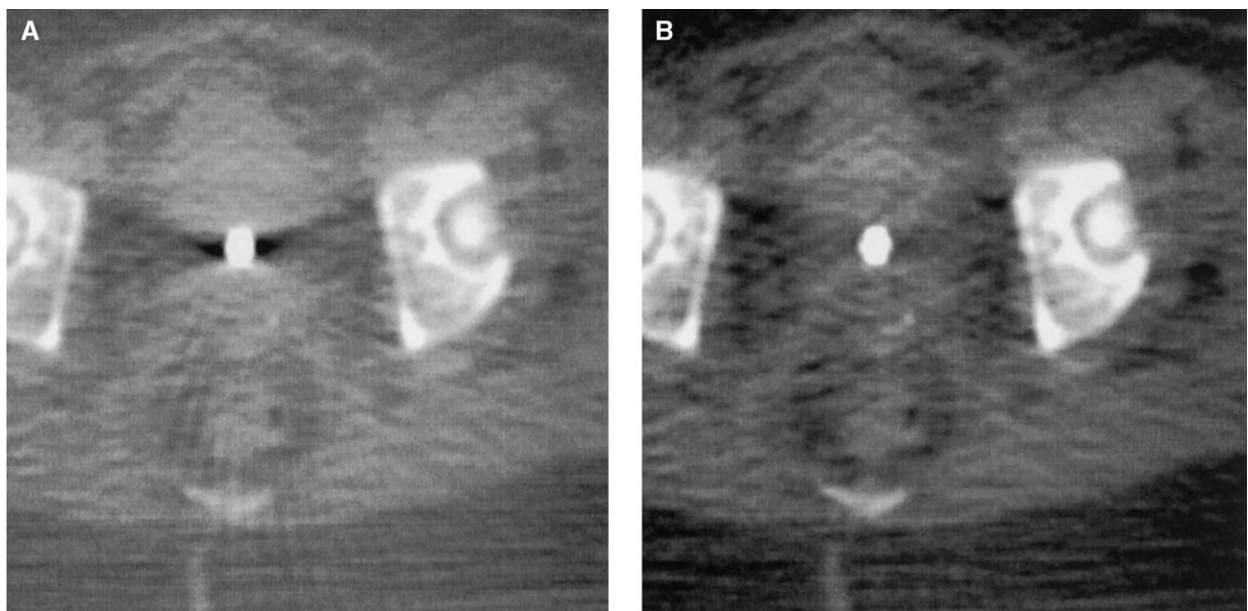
CT scan through the tandem of a Fletcher-Suit applicator (a) before and (b) after artifact reduction.
